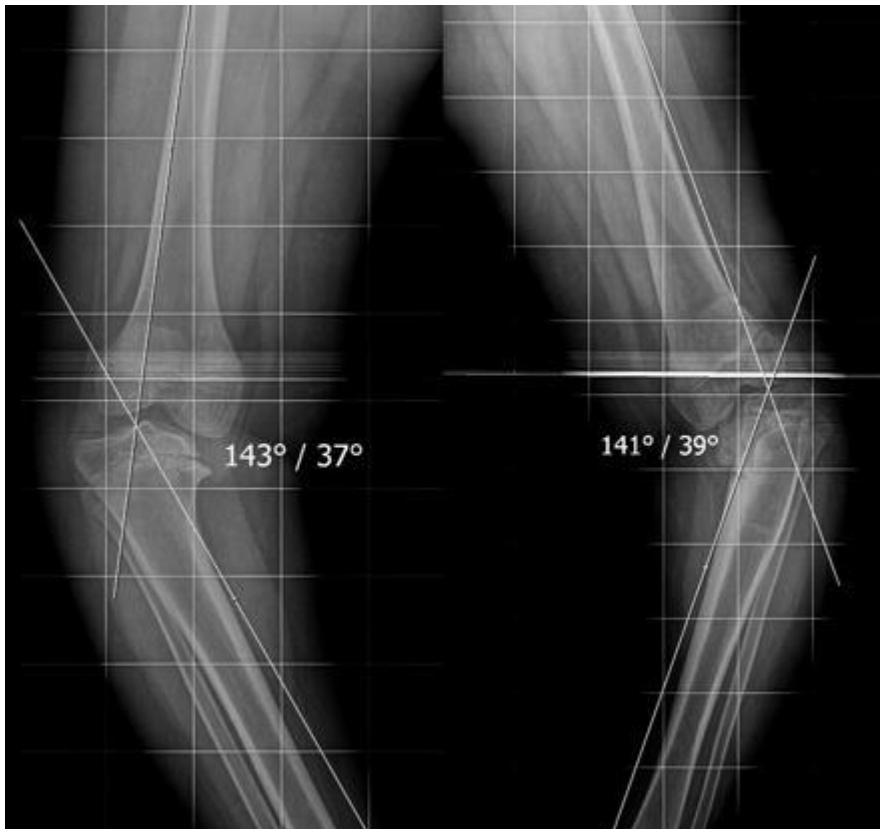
Radiograph demonstrating the method of measuring the tibio-femoral angle used in diagnosing Blount's disease.⁽³⁾
